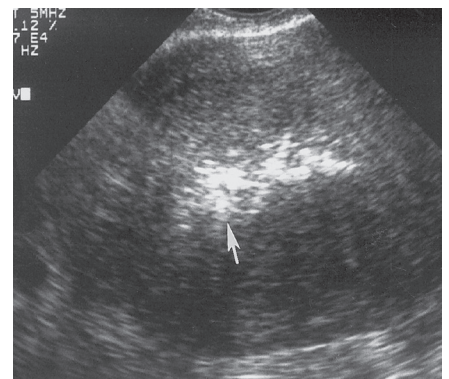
Ultrasound image shows echogenic material with posterior acoustic shadowing (arrow), a finding that is consistent with calcified retained products of conception.
